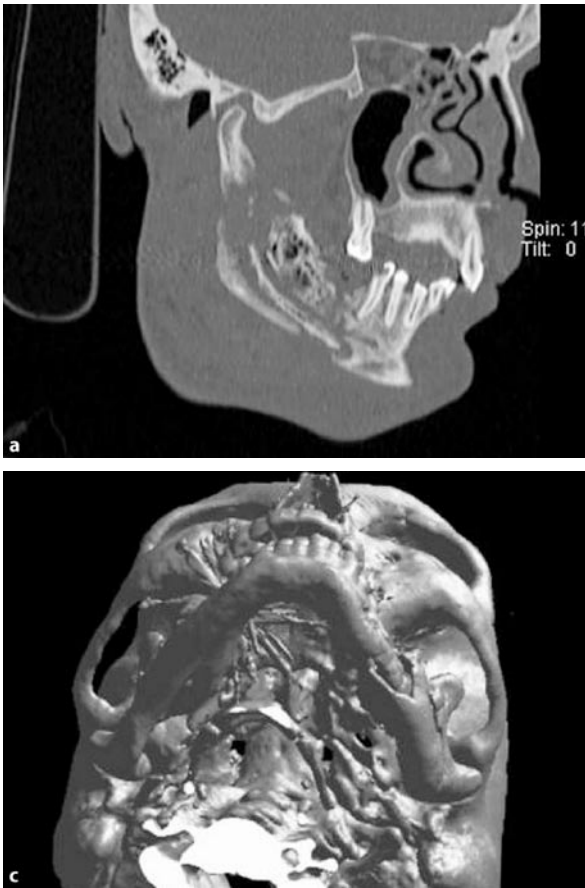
The CT scans of a patient with secondary chronic osteomyelitis of the left mandible developing a giant sequestrum on the bases of the mandibular corpus. The progressive infection has weakened the bone and hence a pathological fracture has resulted. Sagittal CT scan (a) and 3D reconstructions (b,c). (Courtesy of N. Hardt)
